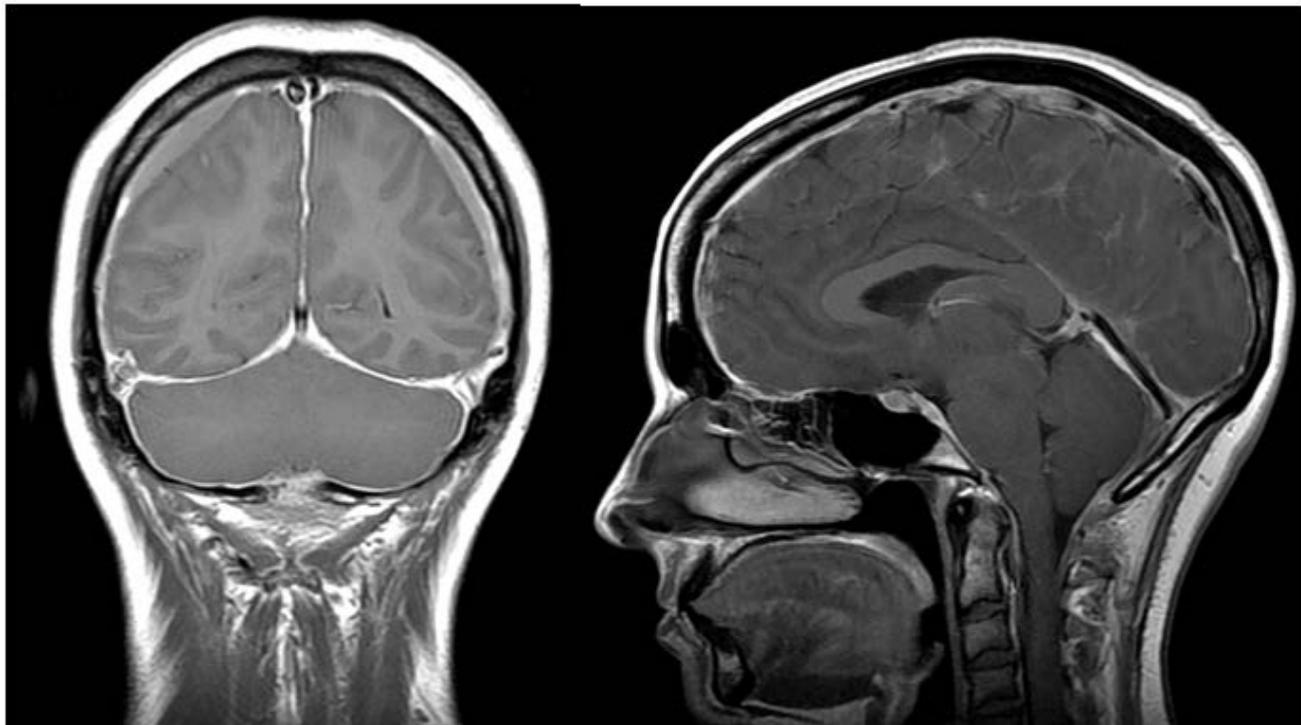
Gadolinium-enhanced T1 weighted MRI image demonstrating diffuse pachymeningeal enhancement and bilateral subdural fluid collections. a) Coronal view. b) Sagittal image with mildly prominent pituitary gland and brain sagging
